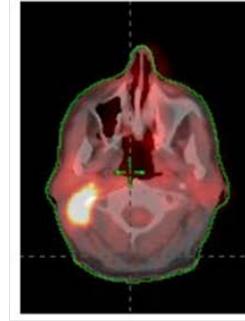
PET/CT Fusion axial images (1a-1d) and sagittal and coronal images (1e & 1f) of patient with a PET+ necrotic node on right posterior triangle of the neck. Note entirely negative respiratory mucosa. University of Massachusetts Medical School, Department of Radiation Oncology.
